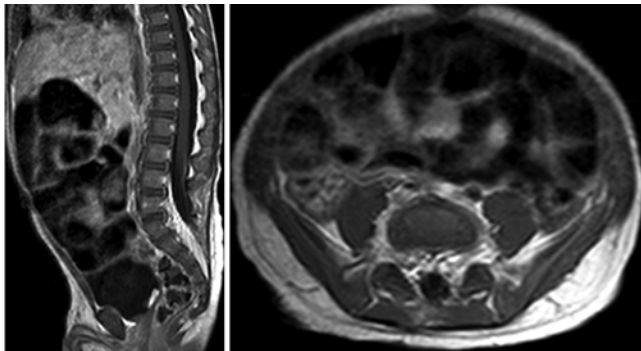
At 16 months following the biopsy, sagittal (left) and axial (right) MR images show essentially complete resolution of the mass.
